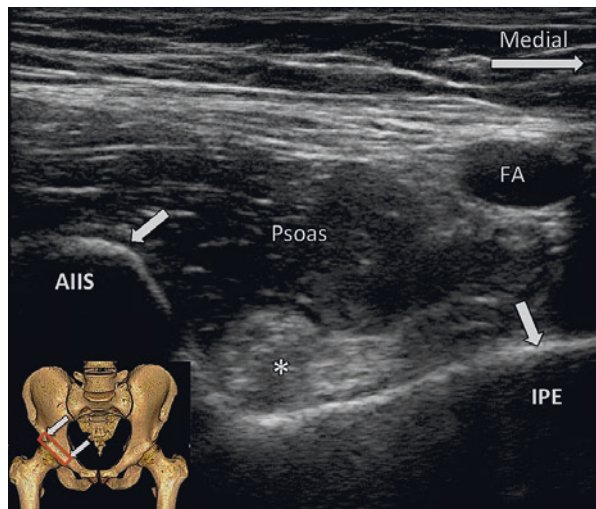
Sonographic image when aligning the ultrasound probe with AIIS and IPE (both indicated by bold arrows). Psoas tendon is marked by the asterisk. FA, femoral artery. (Reprinted with permission from Philip Peng Educational Series)
